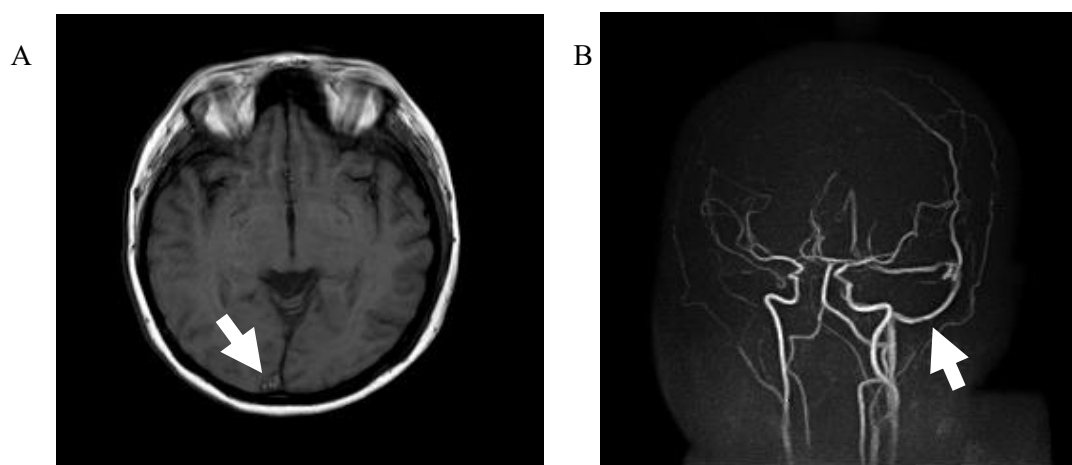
Non-Contrast Head MRI and MRA
